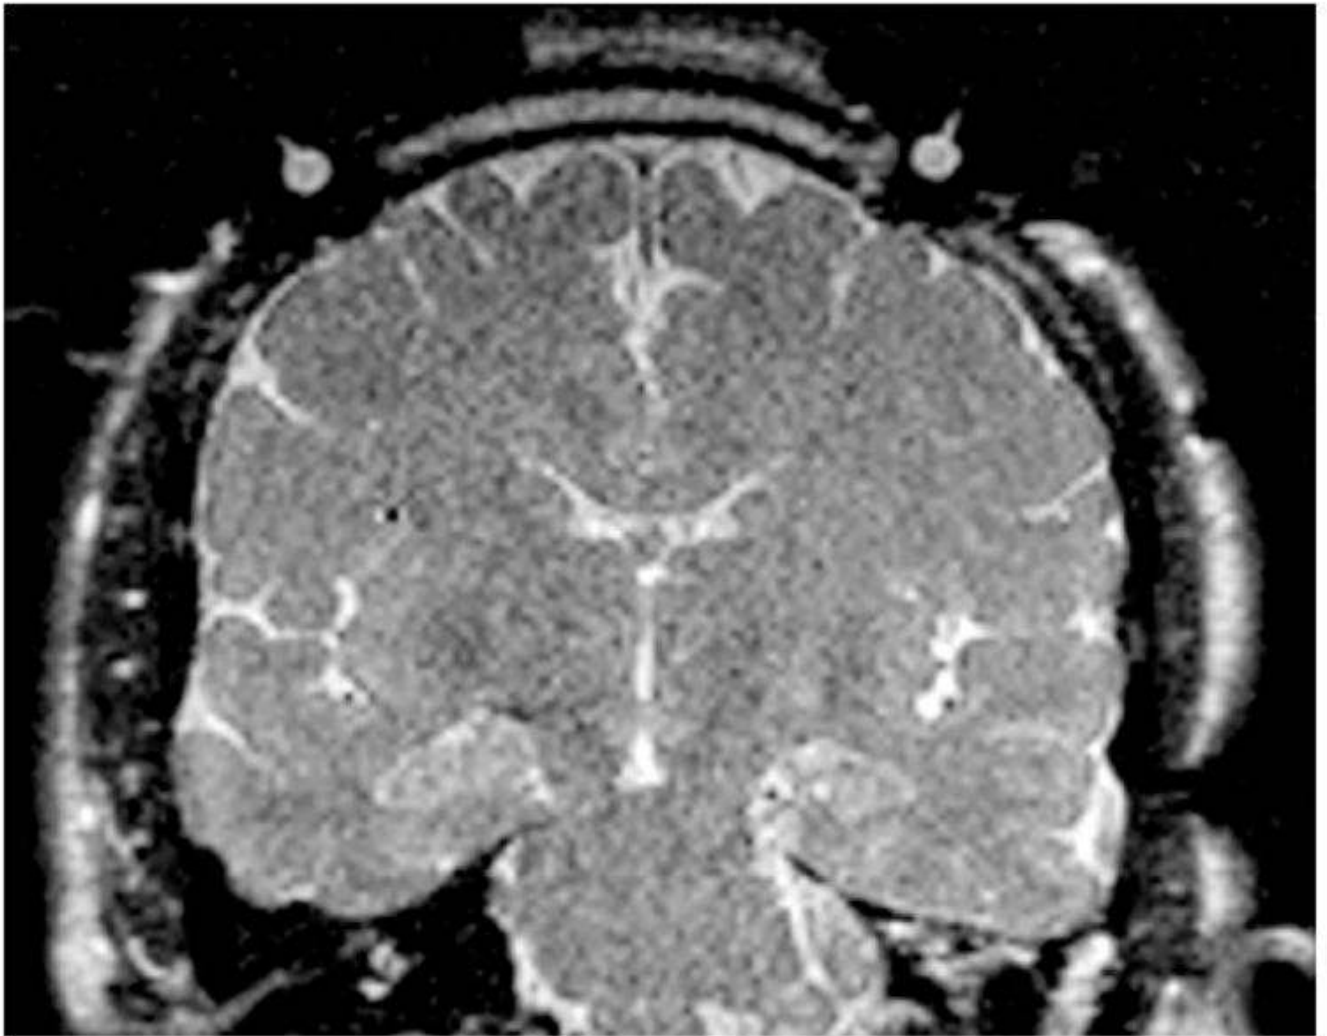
Coronal MR image used to define the coordinates of the pivot points for the trajectory guides, prior to aligning the alignment stem (MR protocol 4).
